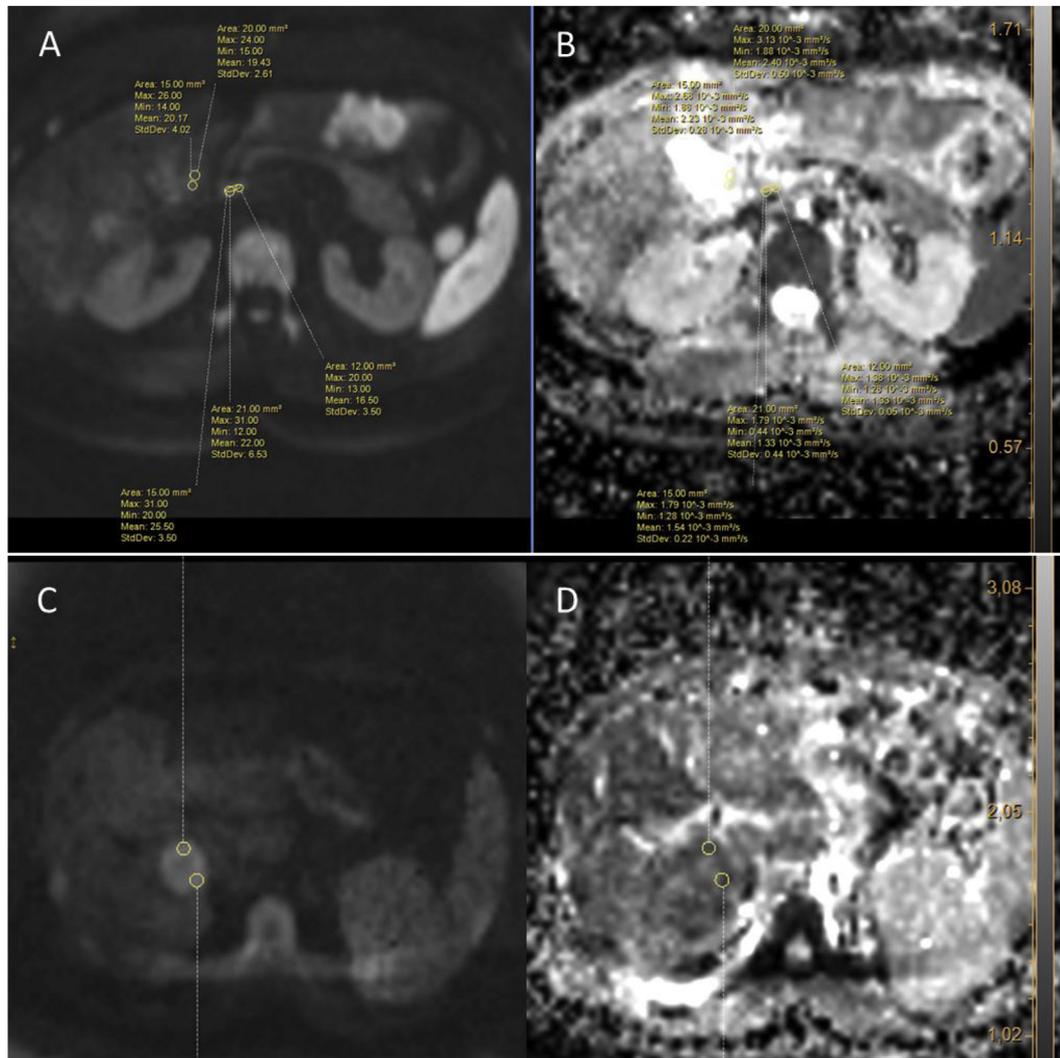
Examples of ADC measurements in the DWI and ADC maps images. A-B. Measurement of nodes in the hepatic pedicle and retropancreatic area (stations number 12 and 13 according to the “Japanese classification for Gastric Cancer” [23]). On the left the trace image with low B0 is used to place the ROI of 15–20 mm² diameter in the center of the node, the software automatically matches the ROI in the ADC maps (right) and the measure of ADC is recorded. C-D. A measure of ADC taken in a liver metastasis. The ROI is placed on the rim of the node with the aim to avoid the liquefied central part of the lesion.
